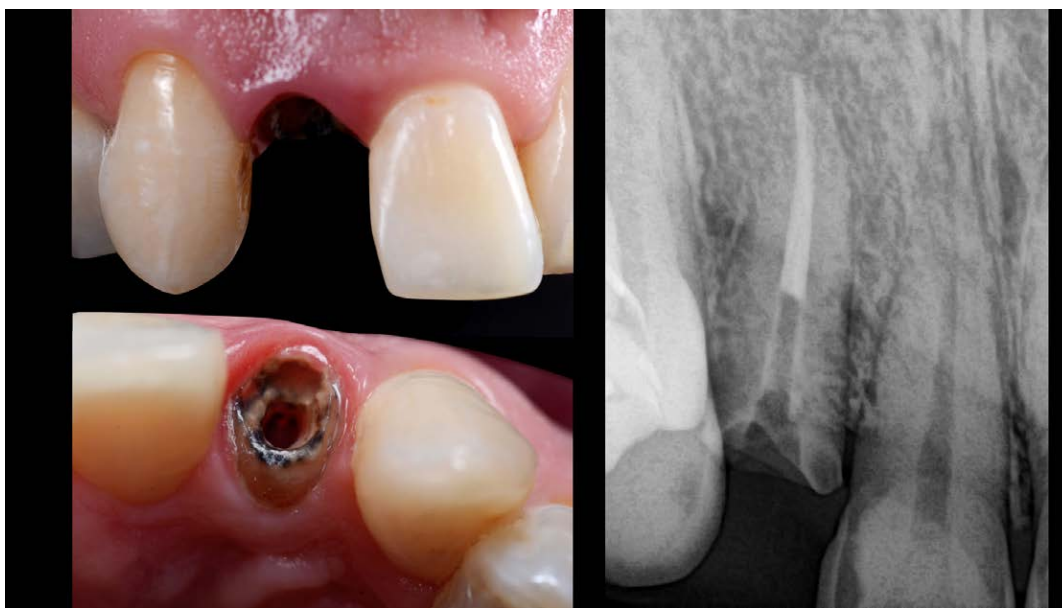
Preoperative labial and occlusal views of coronal fracture on tooth 7 with invasive margins evident in the vicinity of the alveolar ridge. Initial radiograph examination.
